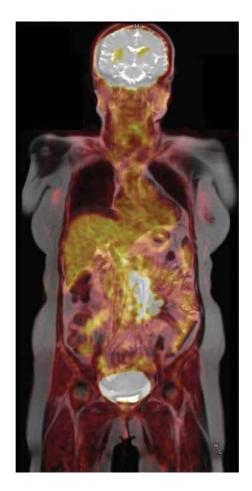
PET/MRI scan demonstrating recurrent ovarian cancer with para-aortic lymph nodes involvement. MRI gives good soft tissue resolution of the FDG avid lymph nodes noted at central abdomen.
